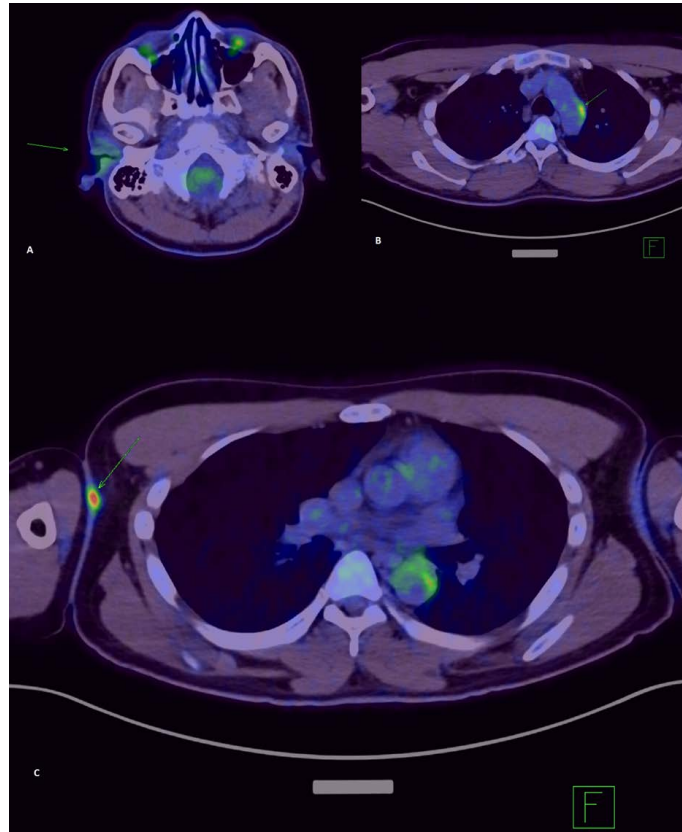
¹⁸F fluorodeoxyglucose PET CT demonstrating avid FDG uptake in the right external acoustic meatus (A), para-aortic node (B) and skin along the right chest wall (C). *TECHNIQUE:* 5.87 mCi of F18 Fluorodeoxyglucose; CT – 100.0kV; Automatic Exposure Control: average 330.0 mA; Slice thickness 3.0mm
